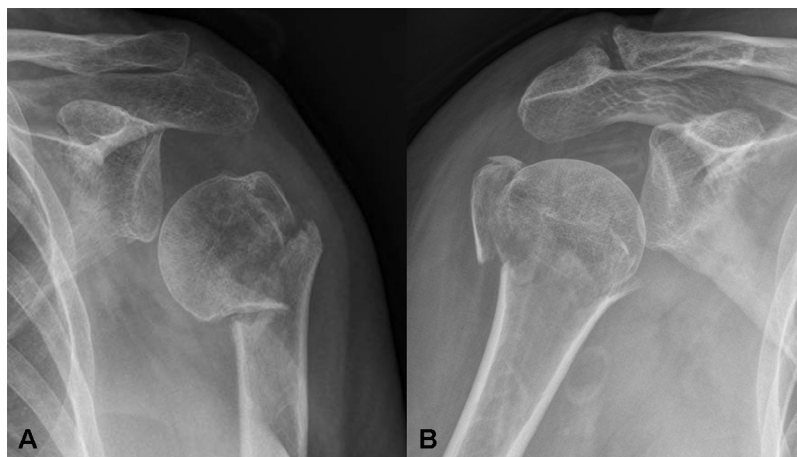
(A) Representative anterior-posterior radiograph of a Neer 2-part¹¹ proximal humerus fracture in varus (neck-shaft angle of <120°). (B) Representative anterior-posterior radiograph of a Neer 4-part¹¹ proximal humerus fracture in valgus (neck-shaft angle of >150°).
